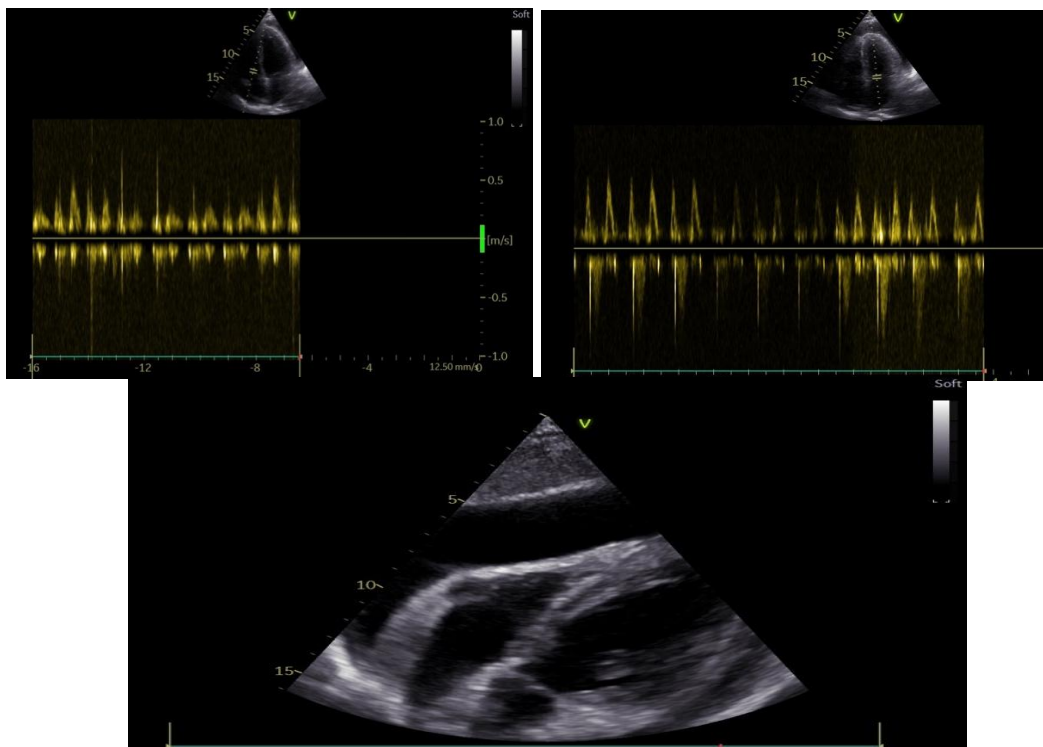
Echocardiographic findings: Large pericardial effusion 26 mm at the RV level, with significant mitral 25% and tricuspid 50% respiratory flow variation
